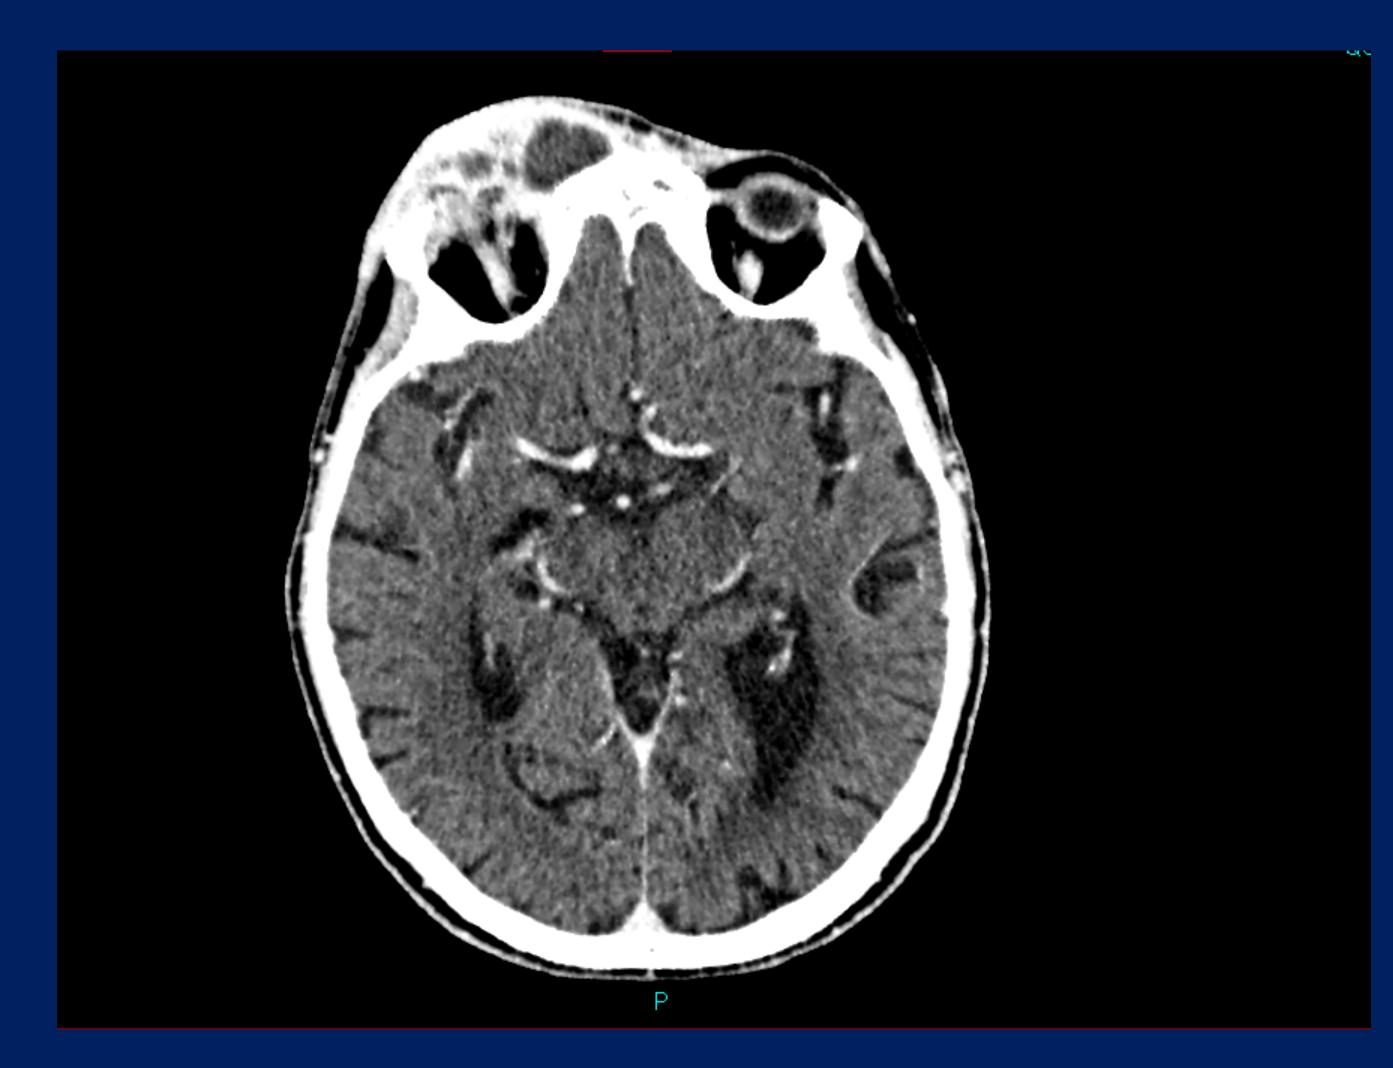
CT Head with contrast. 4.3 x 2.3 x 2.9cm multiloculated abscess overlying medial right orbit and frontal sinus with underlying destruction of the anterior wall of the right frontal sinus. Chronic inflammatory changes consistent with pansinusitis. Periorbital cellulitis and thickening of the right superior oblique muscle but no clear orbital abscess.
